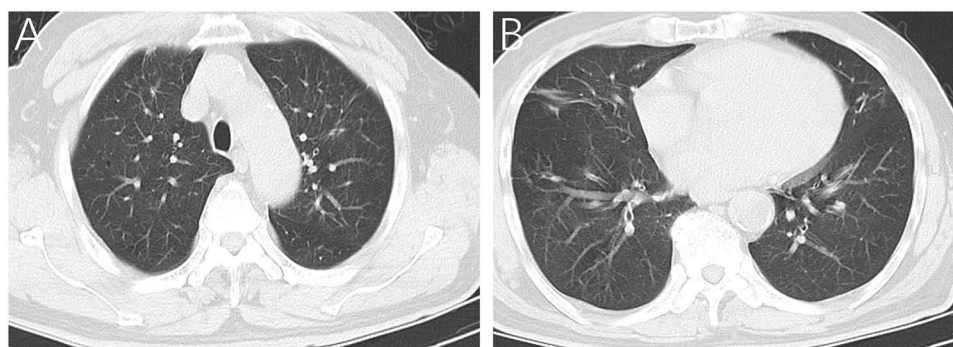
Chest CT at 10-year follow-up. The bilateral upper lung fields show normal lucency, with no evidence of patchy consolidations, ground-glass opacities, nodules, or fibrous streaks (A). The bilateral middle and lower lung fields also appear normal, with complete resolution of all previous lesions (B). [L] indicates the left side of the lung.
